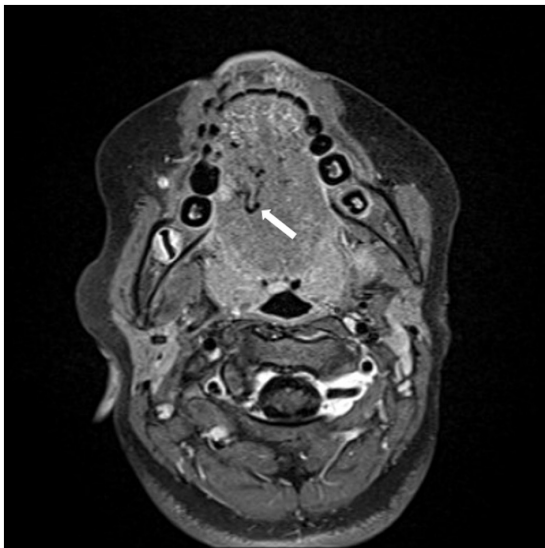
Incidental finding of a large-diameter vessel in a type CII vascular anomaly. The axial contrast-enhanced T1-weighted image with fat saturation is shown, demonstrating a large-diameter vessel (white arrow) in the right tongue.
